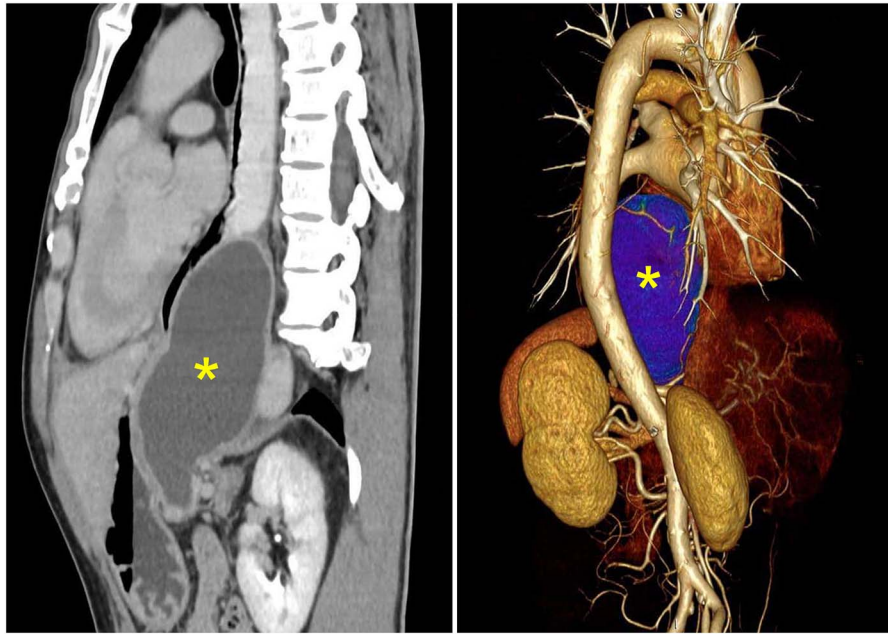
Sagittal and 3D-reconstruction CT images show a cystic structure extending from the pancreatic tail through the esophageal hiatus of the diaphragm into the mediastinum; this mass is located posteriorly to the esophagus and stomach, compressing the esophagus, and pushed the heart forward.
